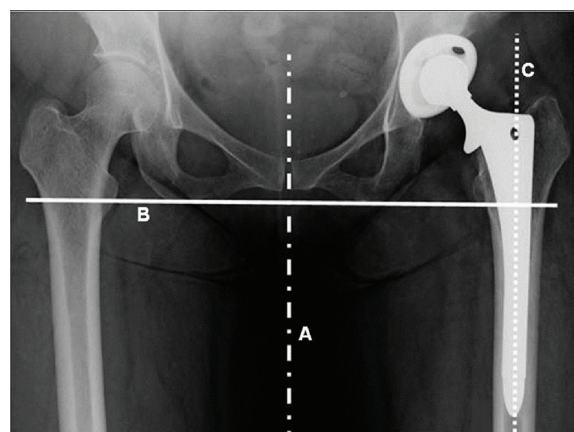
Hip AP x-ray (A) midline vertical axis, (B) inter-ischial line, (C) femoral shaft axis.
